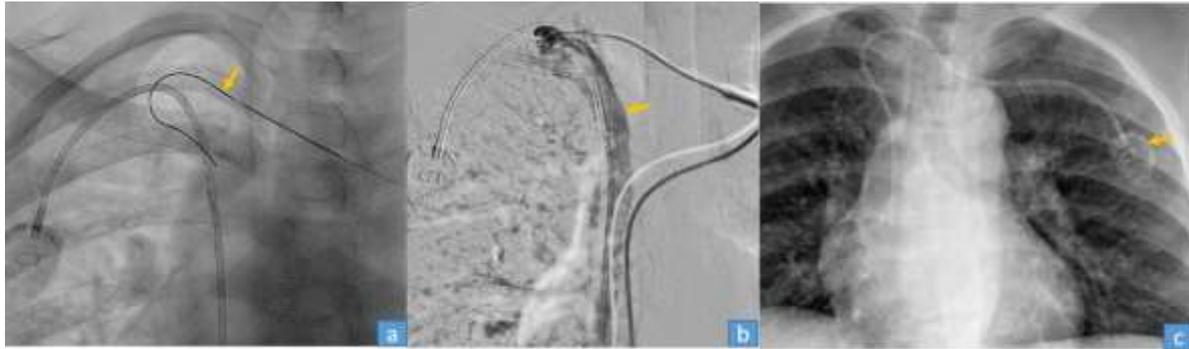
(a) Initial fluoroscopic image showing the micropuncture guidewire coursing from the horizontal limb of the anterior jugular vein to the right brachiocephalic vein (arrow). (b) Venogram DSA study obtained through a 5F sheath demonstrating a patent right brachiocephalic vein and superior vena cava (arrow). (c) Post-central venous port insertion final check radiograph showing the left anterior chest wall central venous port (arrow) in situ, with the catheter coursing from the left to the right side. *DSA: Digital Subtraction Angiography.*
